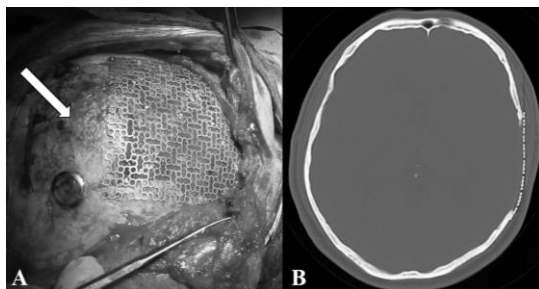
Intraoperative photo showing the bone flap (white arrow) and cranioplasty with titanium mesh (A). Postoperative CT scan showing the cranioplasty (B)
